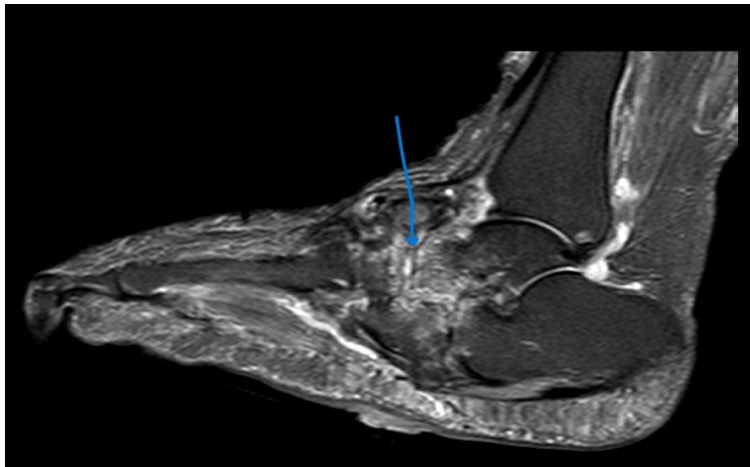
shows MRI of the right ankle in a 66 years old female patient with a history of an ulcer in the dorsal aspect of right foot. The Sagittal Short tau inversion recovery (STIR) image reveals abnormal marrow edema in the tarsal bones (blue arrow) along with destruction and disorganization of intertarsal joints with multiple bony erosions indicative of a Neuropathic joint.
